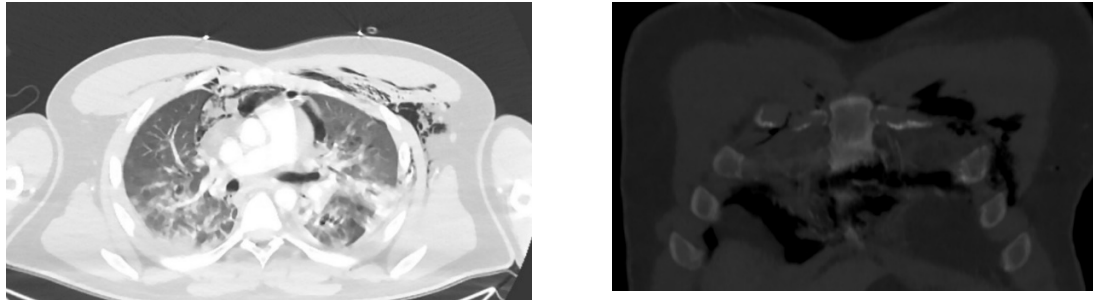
Blunt chest trauma signs. a) Axial CT image in the parenchyma window. A 39-year-old male patient who has pneumomediastinum, chest wall emphysema, pulmonary contusion. Costal cartilage fracture is observed on the right. b) Coronal reformatted CT image in the bone window. Fracture in the right 3rd costal cartilage.
